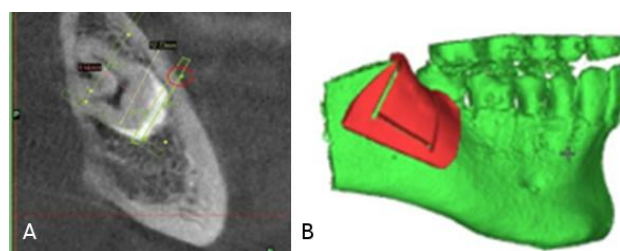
A) CBCT as DICOM files with virtual surgical planning determining the vertical cutting plans; B) Matic software with bone - borne cutting guide with the virtual cutting slots
